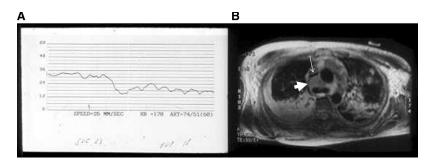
Case of an 18-yr-old man with relapsed acute T-cell lymphoblastic lymphoma and superior vena cava (*SVC*) syndrome. *A*, Diagnosis of SVC syndrome was first made by passing a pulmonary artery catheter through the obstruction with balloon deflated and measuring a drop in pressure from 33 to 18 mm Hg. *B*, Magnetic resonance imaging obtained the next day confirmed a large mediastinal mass (*thick arrow*) compressing the SVC (*thin arrow*). Courtesy of the Greenebaum Cancer Center and the Department of Radiology, University of Maryland School of Medicine.
